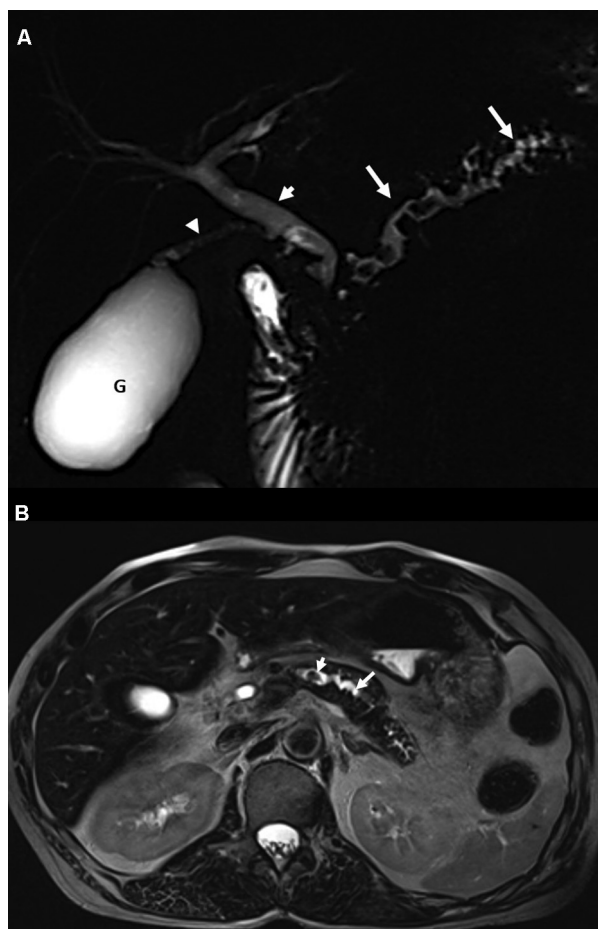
Magnetic resonance (MR) in alcohol-related chronic calcific pancreatitis. (A) Three-dimensional (3D) maximum intensity projection (MIP) magnetic resonance cholangiopancreatography (MRCP) shows dilated and tortuous pancreatic duct with dilated side branches (white arrow). There are multiple filling defects in the duct. The short white arrow is common bile duct (CBD), the white arrowhead is cystic duct, and G is the gallbladder. (B) T2-weighted (T2W) SPACE thin high resolution shows an atrophic pancreatic gland with a dilated and tortuous pancreatic duct (long white arrow). Filling defects in the pancreatic duct are calculi (short white arrow).
